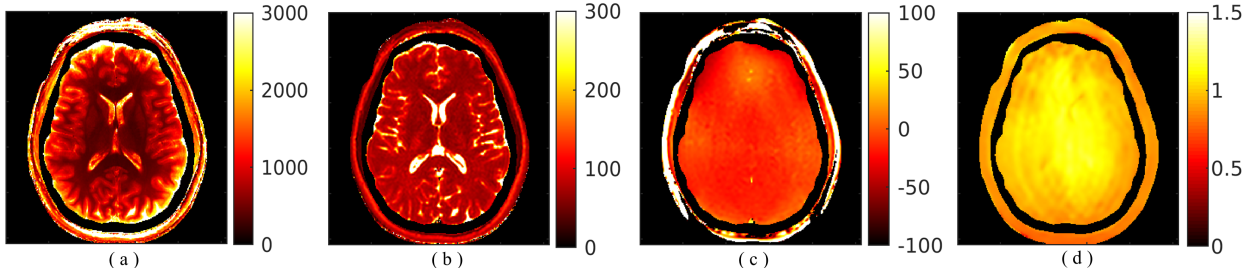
Quantitative brain maps computed from the Multi-Modal MRI Reproducibility Resource: (a) T_1 (ms), where T_1 values from 3000 ms to 4000 ms are shown as equal to 3000 ms; (b) T_2 (ms), where T_2 values from 300 ms to 2500 ms are shown as equal to 300 ms; (c) B_0 (Hz), where B_0 values less than $|500|$ Hz are shown as equal to $|100|$ Hz ; (d) B_1^+ .
